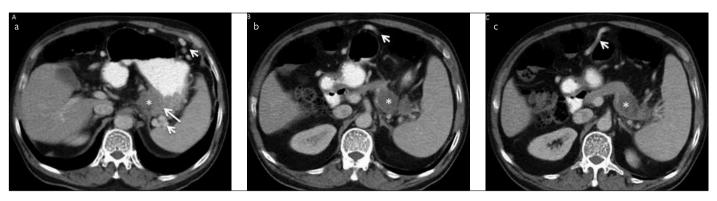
a-c. A 66-year-old man with gastric cancer extending through the course of short gastric veins. Serial axial contrast-enhanced CT images demonstrating the main tumor (long arrow, a), and tumor infiltrating through the course of short gastric veins (asterisks, a-c). Tumoral occlusion of the splenic vein is clearly seen (asterisk, c). Dilated collateral veins due to splenic vein occlusion (short arrows, a-c)
